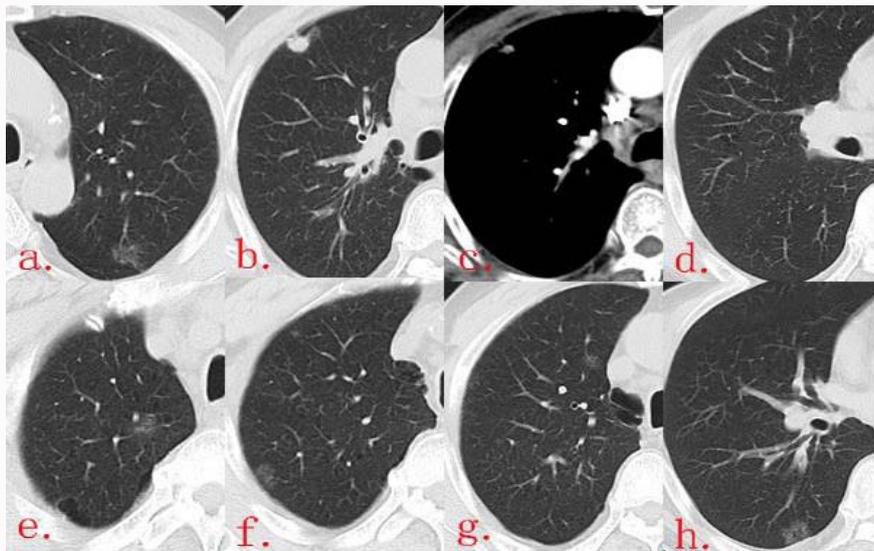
The CT images of Pulmonary Nodules in 2019.3. (a) pGGN in apical or posterior segment of left upper lobe (13 mm). (b) Solid nodule in anterior segment of right upper lobe (13 mm \times 10 mm) in lung window. (c) Solid nodule in anterior segment of right upper lobe in mediastinal window. (d) Disappeared solid GGNs in posterior segment of right upper lobe. (e) pGGNs in apical segment of right upper lobe (7 mm) (f-h) New SSNs developed in apical segment of right lobes.
